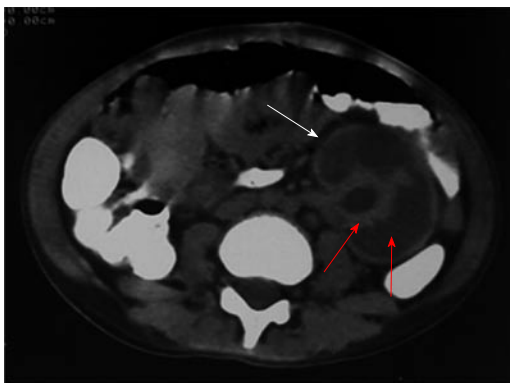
Contrast enhanced computed tomography showing diffuse cortical necrosis in solitary left kidney after road traffic accident in a child aged 11 years. This image shows isoattenuated peripheral cortical rim (white arrow) and hypoattenuated parenchyma (red arrow).
